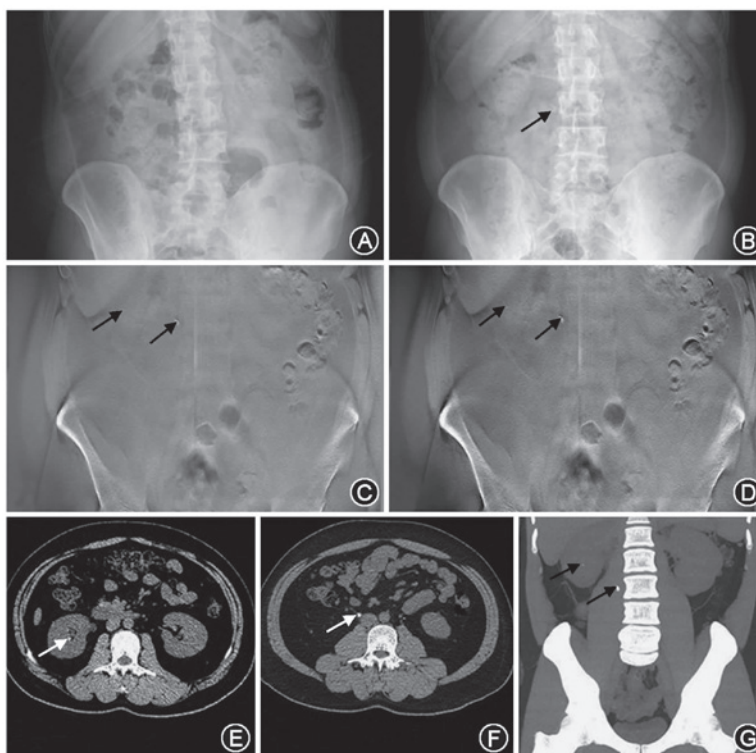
UMDCT, CT and DTS images coupled with KUB radiographs from a 31-year-old male patient diagnosed with urinary tract calculi. (A) No calculi were detected from the KUB radiograph on the unprepared bowel. (B) KUB radiography on prepared bowel detected a calculus on the right ureter (black arrow). DTS detected a right ureter and a right kidney calculus (C) prior to and (D) following bowel preparation (black arrows). (E) CT images detected a right kidney calculus (white arrow). (F) CT images detected a right ureter calculus (white arrow). (G) An MRP MIP reconstruction image of UMDCT detected a right kidney and right ureter calculus (white arrow). UMDCT, unenhanced multidetector computed tomography; CT, computed tomography; DTS, digital tomosynthesis; KUB, kidneys-ureters-bladder.
